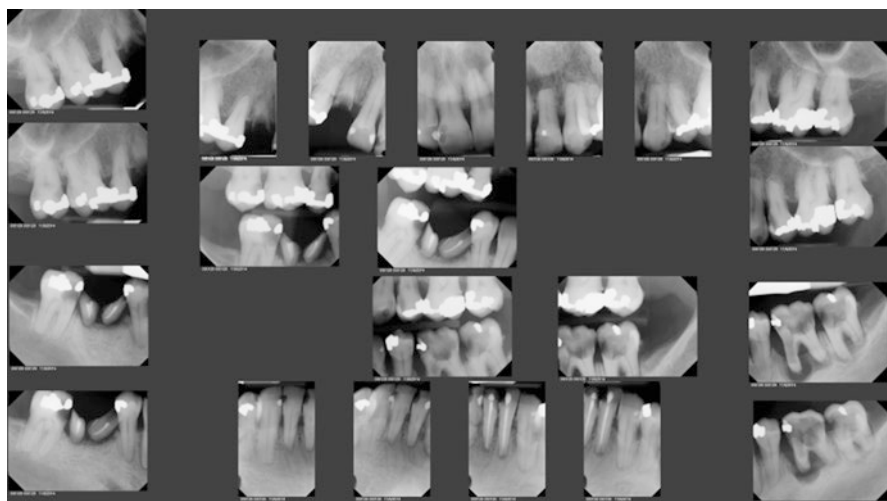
The periapical radiograph of a person with a 10-year history of meth use (4–5 times daily). Note the level of tooth decay activity and broken teeth
